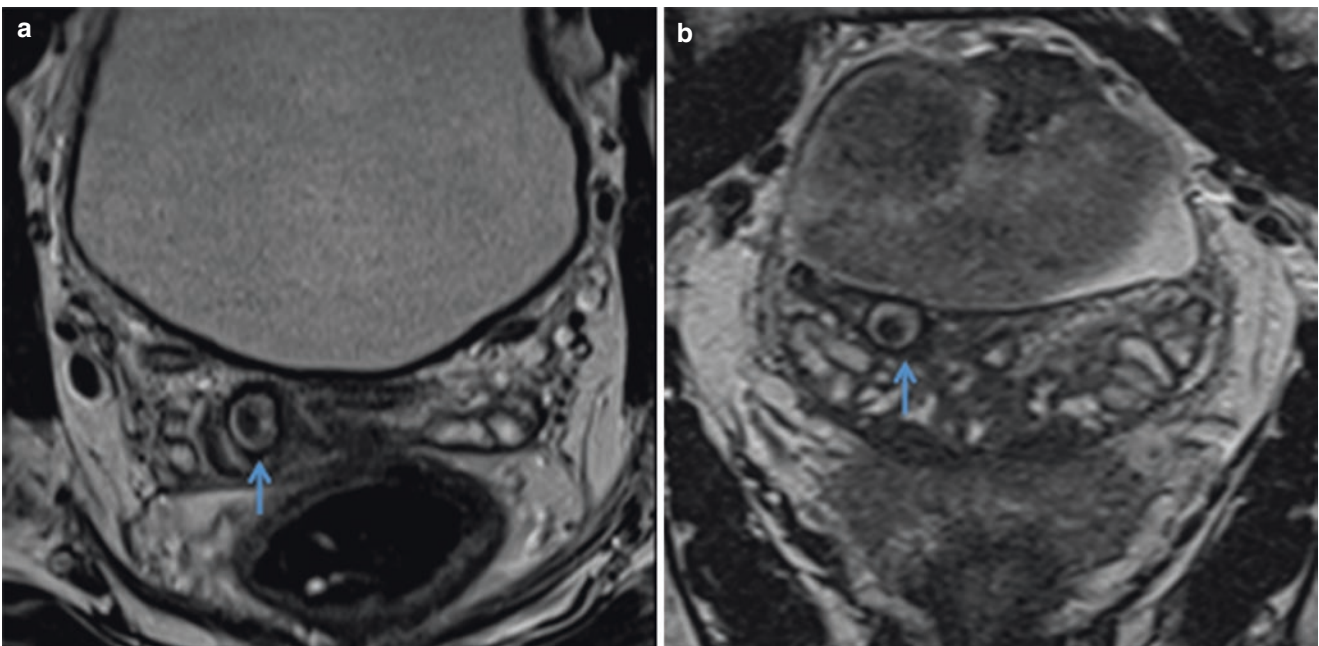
Calculi in a 29-year-old man with hematospermia. Axial (a) and coronal (b) T2-weighted MR image shows calculi in the right ED (arrows)
